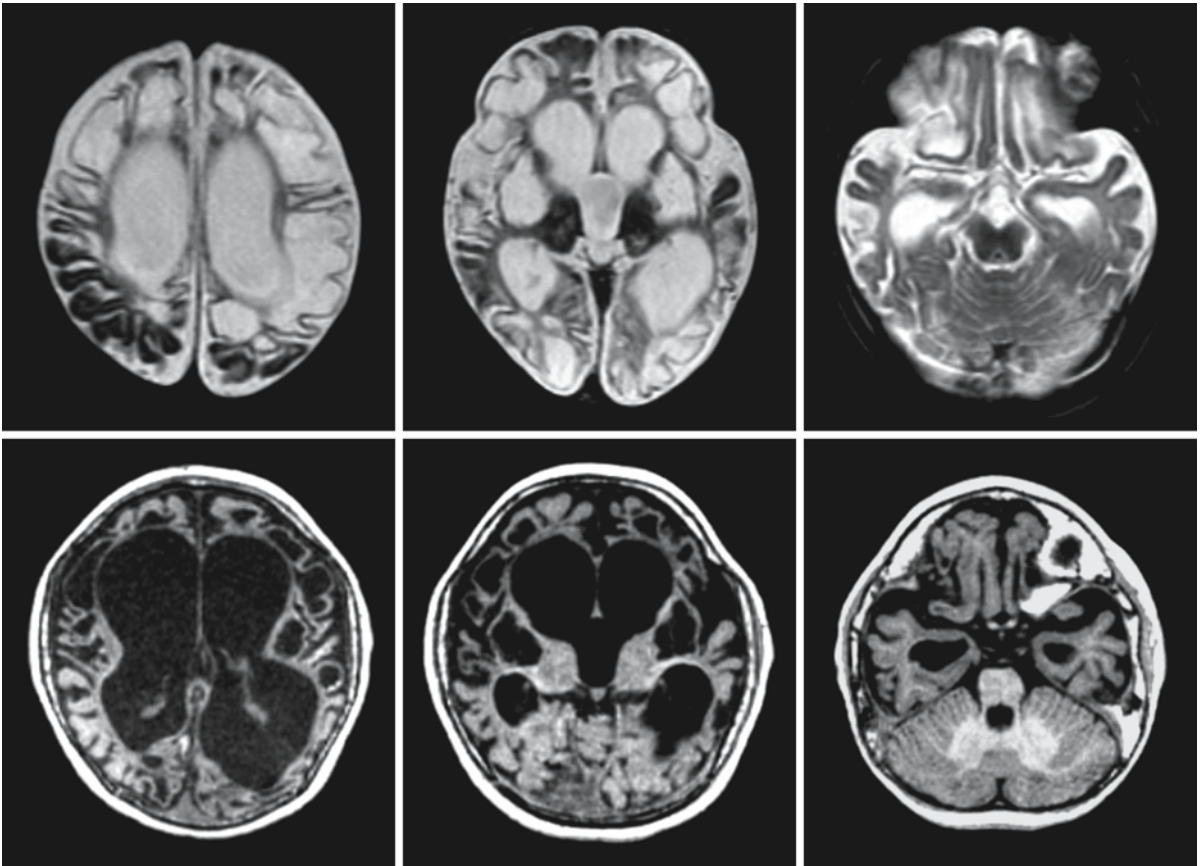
A boy was born at 42 weeks' gestation. An initially mild hypoxic–ischemic encephalopathy was soon followed by a catastrophic encephalopathy. This MRI at the age of 2 years shows a multicystic encephalopathy and ventriculomegaly. The basal ganglia are also cystic. The brain stem and cerebellum are spared
